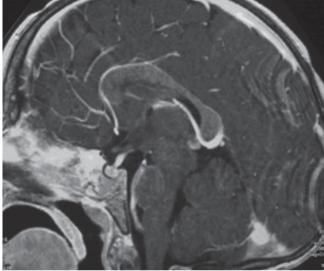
MRI performed at the time of development of diabetes insipidus in a child followed with history of LCH. The pituitary stalk is shown thickened
